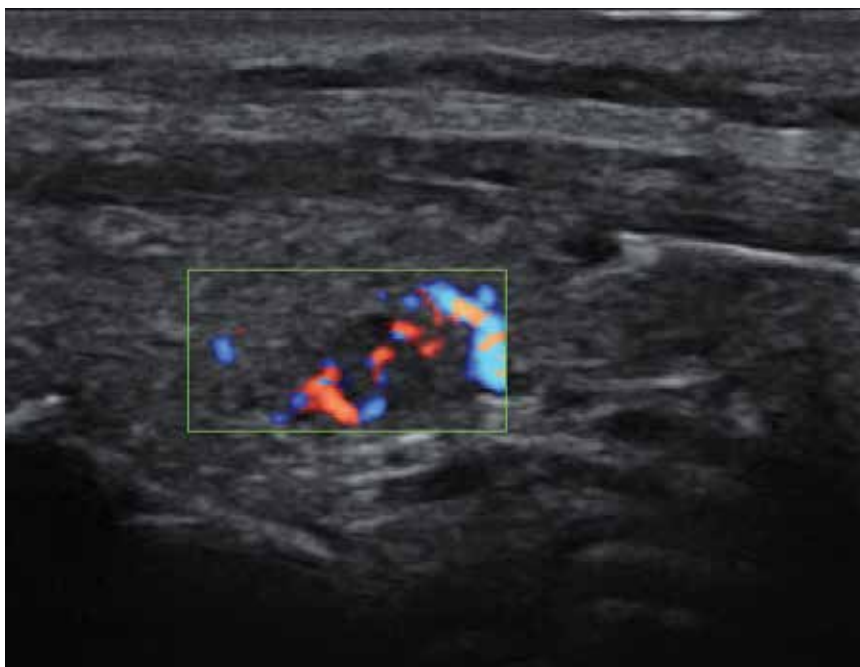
Intra-thyroid parathyroid adenoma demonstrated on ultrasound image. Image courtesy of Division of Medical Imaging, Flinders Medical Centre
